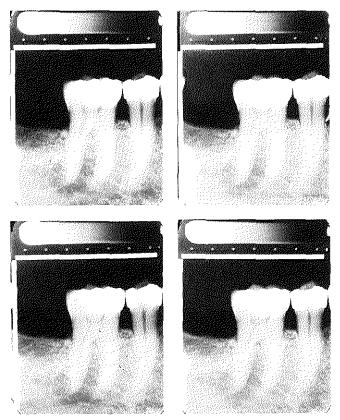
Four radiographs taken at intervals of 3 months.
